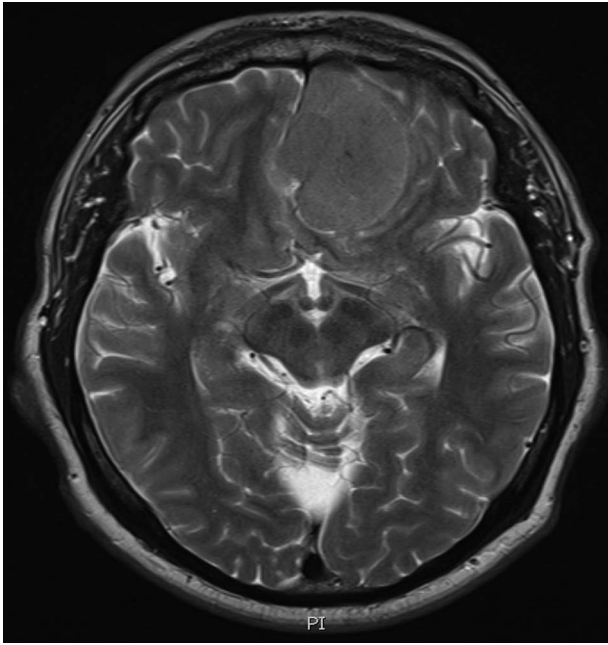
MRI Head—Subsequent MRI imaging of the brain which showed progression of the mass with associated bony lysis.
